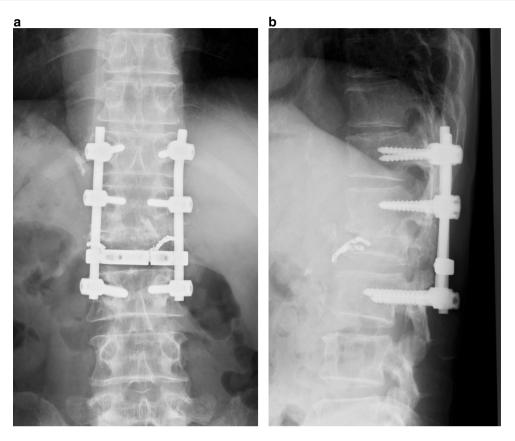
Posteroanterior (a) and lateral (b) plain radiographs of the lumbar spine 2 years after the surgery revealed bone union
